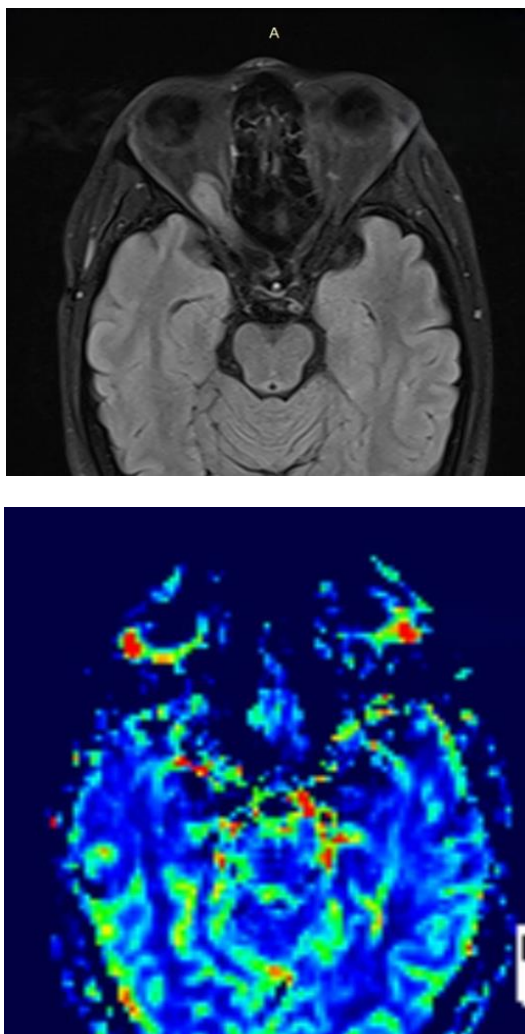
Patient U., 25 years old, magnetic resonance imaging fragment.
